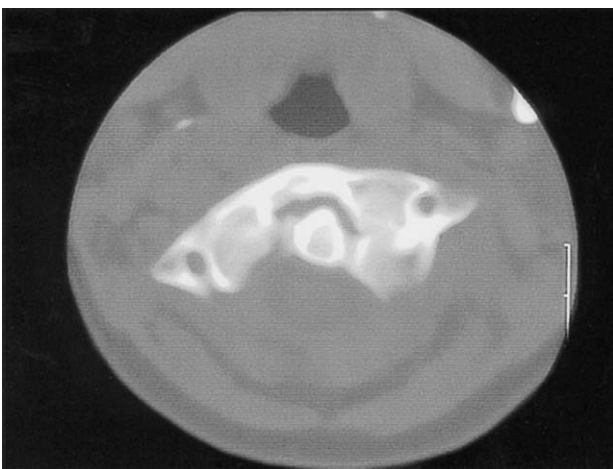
Axial CT scan of the second patient showing the rotational deformity of the C1-C2 complex with an angle of 25°.
